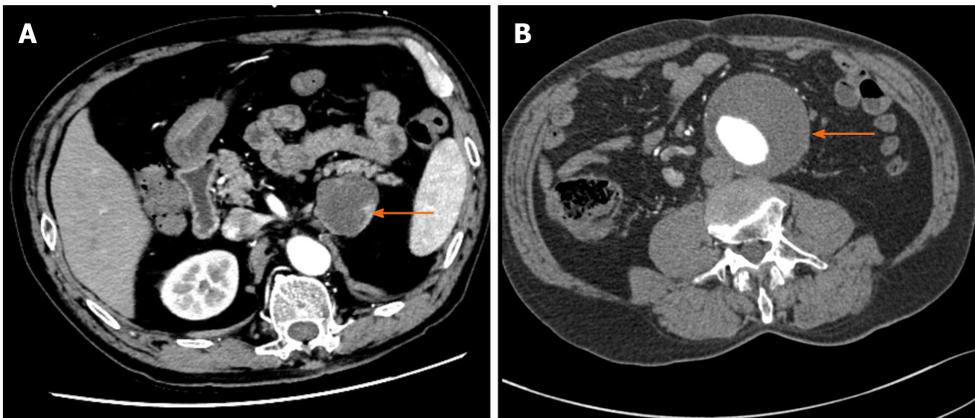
Enhanced computed tomography images. A: Enhanced computed tomography (CT) of the abdomen showing a round-like mass (4.4 cm × 4.3 cm) (orange arrowhead); B: Enhanced CT of the abdomen depicting a 7.0 cm × 7.3 cm abdominal aortic aneurysm (orange arrowhead).
